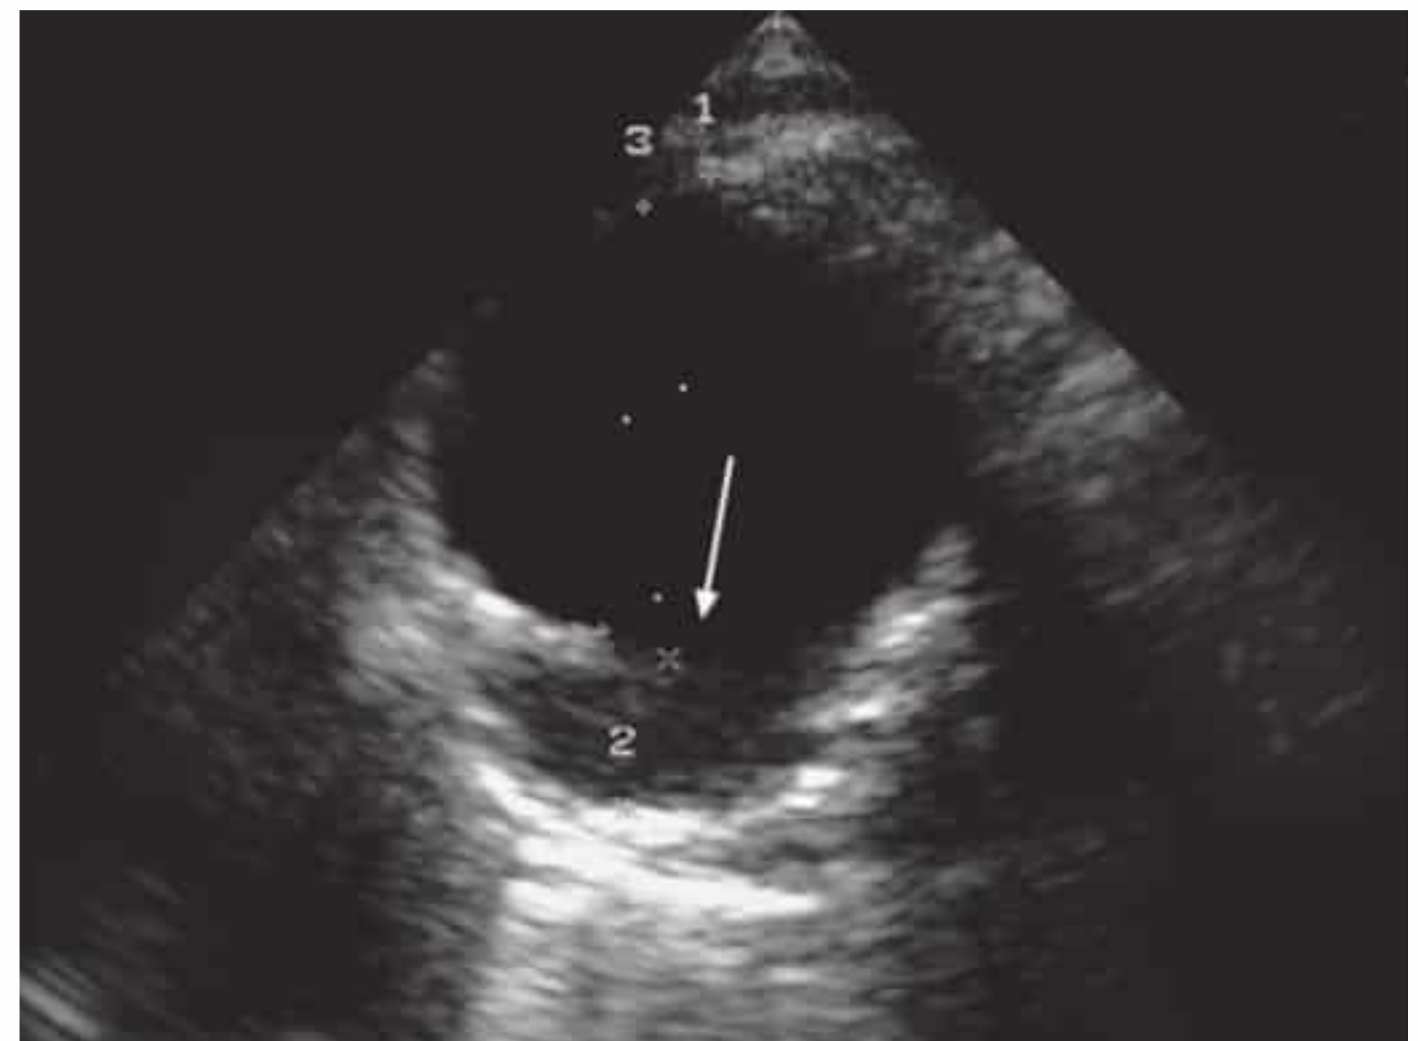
Transesophageal echocardiogram of a penetrating aortic ulcer (arrow, probe at 36 cm from incisor teeth).
